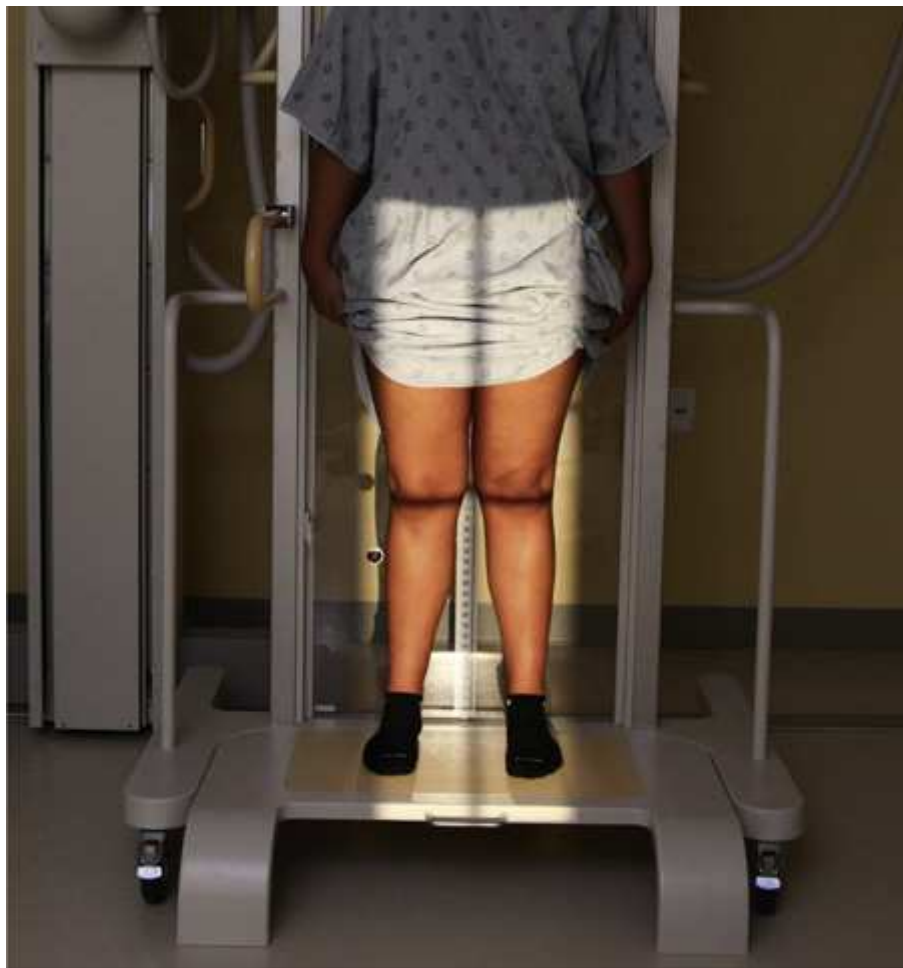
Patient in position for radiograph of lower extremities: hips, knees, and ankles. The patient is placed in the anatomic position. The patient is standing on a raised platform so that the ankles are included.
